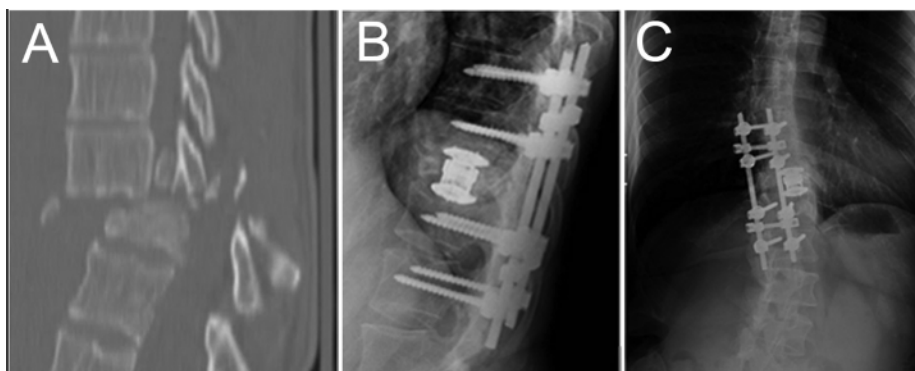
Preoperative (A) and postoperative (B and C) images of the patient. A: Sagittal thoracic CT scan showing severe T-11 fracture dislocation with local kyphosis and obliteration of the spinal canal. B: Sagittal thoracolumbar radiograph demonstrating the fusion construct after T-11 corpectomy, titanium interbody cage implant placement, and T8–12 posterior spinal fusion. C: Two-year follow-up anteroposterior radiograph showing mild scoliosis without evidence of hardware failure.
